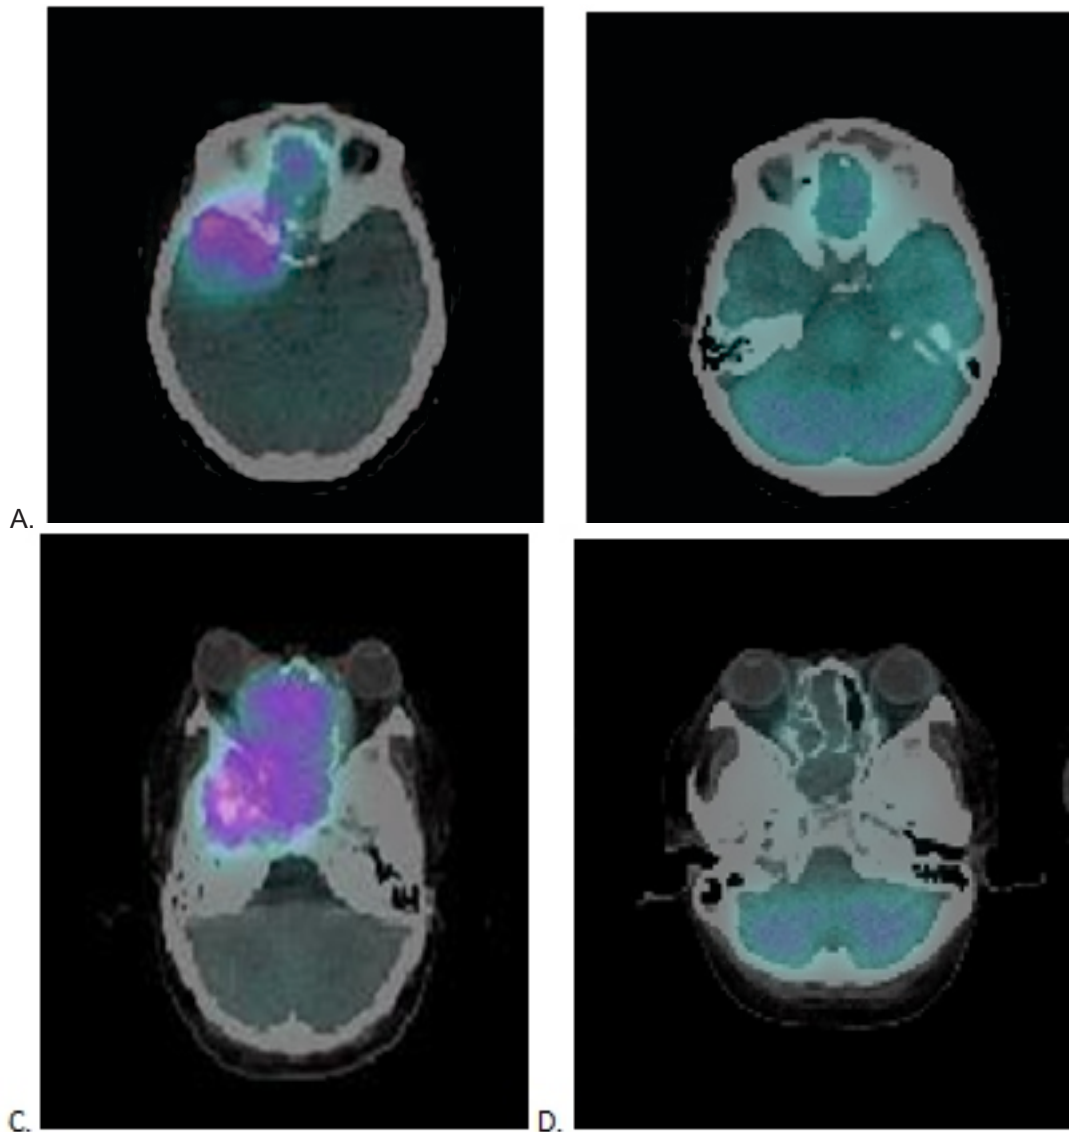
A comparison of the previously seen mass using repeat positron emission tomography-computed tomography (PET-CT) scan. A and C. Previously seen high metabolic activity of the mass in the nasal cavity including the orbital structures, nasopharynx, and facial bones with intracranial extension. C. The previously seen intracranial extension is no longer evident. D. Significant decrease in metabolic activity (SUV 6.1, previously 26.2) and size of the heterogeneously enhancing mass centered in the nasal cavity and ethmoid sinuses. There was also regression in the paranasal sinus extension, stable lytic changes seen in the right posterolateral maxillary sinus wall and other structures around the area.
